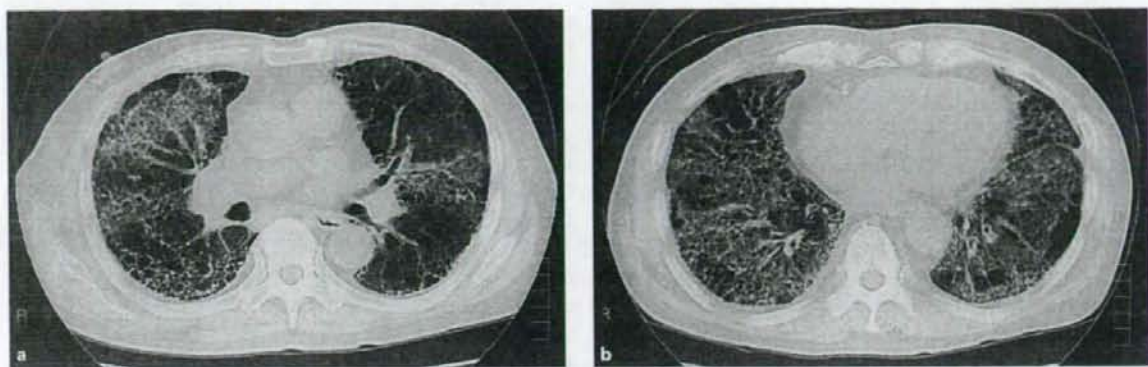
Chest CT taken on admission (August 22, 2003). Diffuse bilateral ground-glass opacities are evident (a) and preexisting honeycombing is observed in the lower lobes (b).
